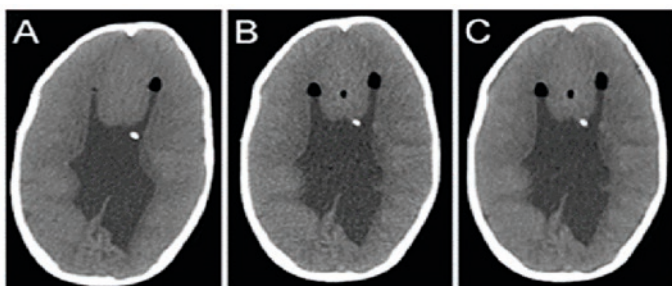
Comparison of the quality of axial head image of a three-year-old child. A - standard CT, B - LDCT, C - LDCT with filter.
